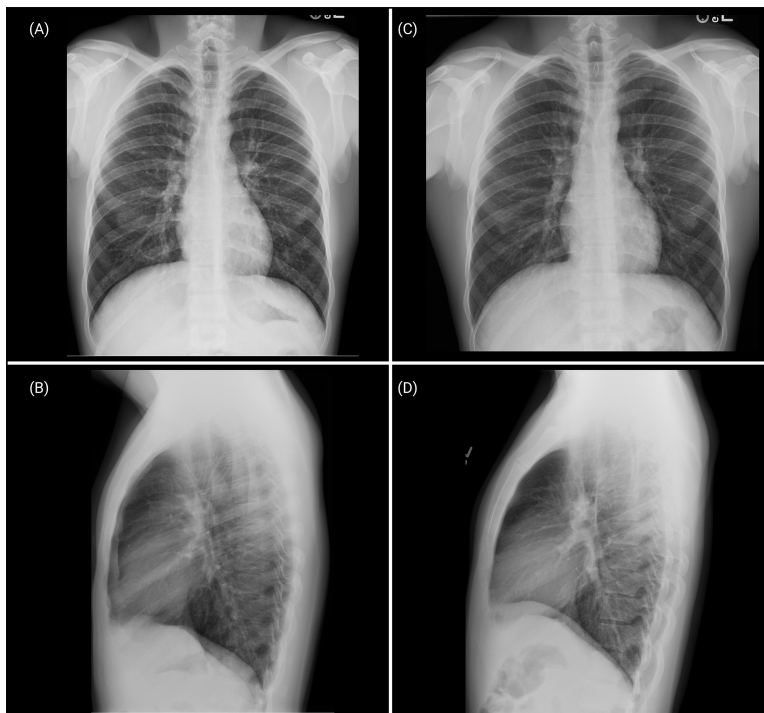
Anterior-posterior and standing lateral X-rays of Twin A (A, B) and Twin B (C, D) 24 h following the inciting SIPE event. Findings include resolving perihilar airspace consolidation, resolution of interlobular septal thickening, sharpened costodiaphragmatic angles, and a modest reduction in cardiac size in both twin candidates. Radiograph formatting performed via licensed Biorender.
